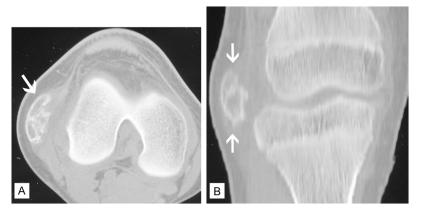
The preoperative CT. On horizontal (A) and coronary (B) view, CT showed a mass (*arrows*) located in the right knee lateral, with the center remaining isodense to normal muscle, and the periphery developing a calcified rim of variable thickness.
